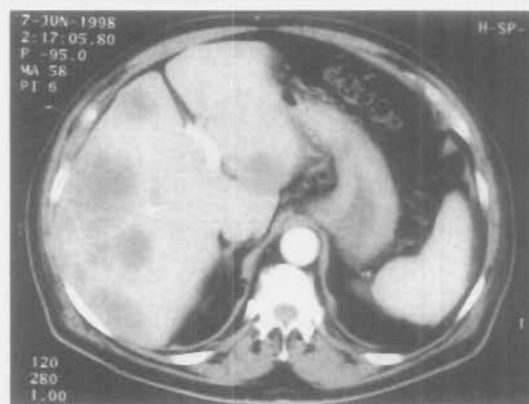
Computed tomogram of the abdomen demonstrating metastatic lesions in the liver.
